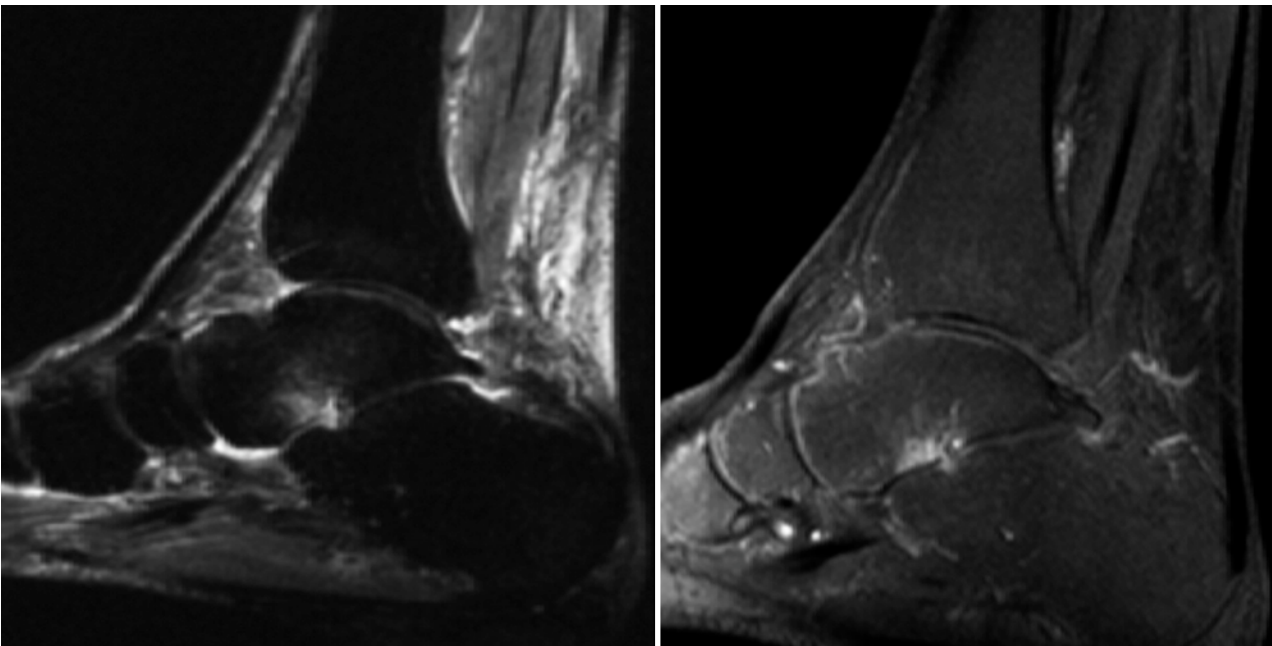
a and b. 4 months after pressure relieving-therapy. Pain and elevated temperature of the right foot had disappeared. MRI shows a significant reduction of bone marrow edema and there were only slight persistent signals in STIR images adjacent to and within the sinus tarsi, and in the subchondral talar area of the ankle joint (Fig. 4a). Fat-suppressed T1 images show a minor slight enhancement within the same region (Fig. 4b).
